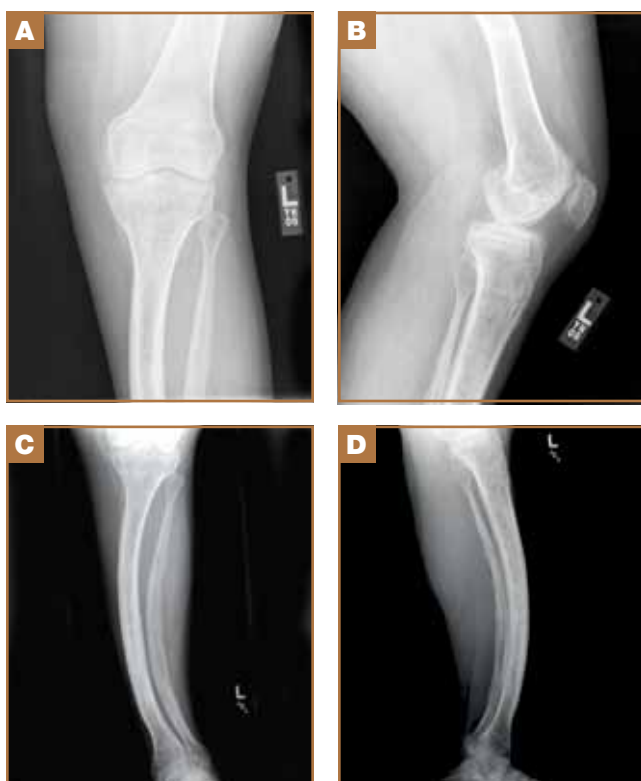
AP and lateral radiographs of the left knee (A, B) and tibia (C, D).
